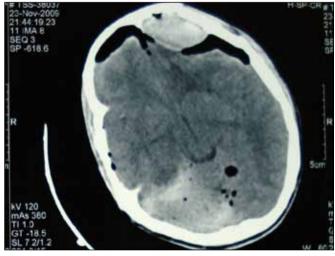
CT scan of Case 1 shows left frontal epidural hematoma with tension pneumocephalus.
